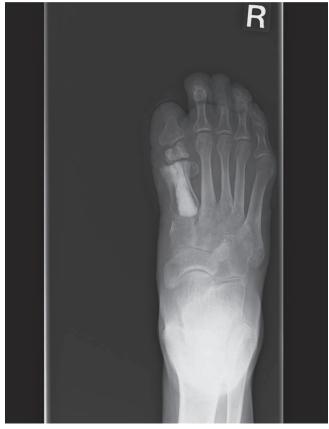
Radiographic image of the non-amputated limb after first metatarsophalangeal joint arthrodesis.
